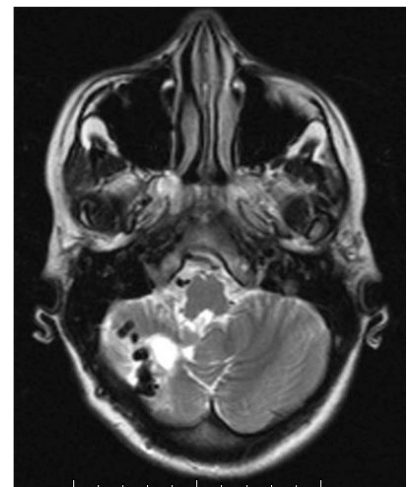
T2W MRI of the brain shows flow voids in the right cerebellar hemisphere in the area of previous resection cavity.
